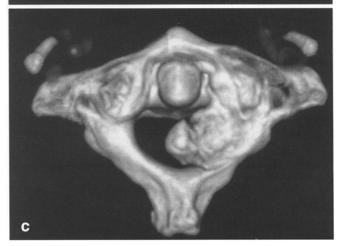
a Axial computed tomography showing an intraspinal bone-like mass (white arrow) arising from the enlarged right lamina of C2; b lateral 3D reconstruction of CT scan showing the tumor (white arrow); c axial 3D reconstruction of CT scan showing the tumor
